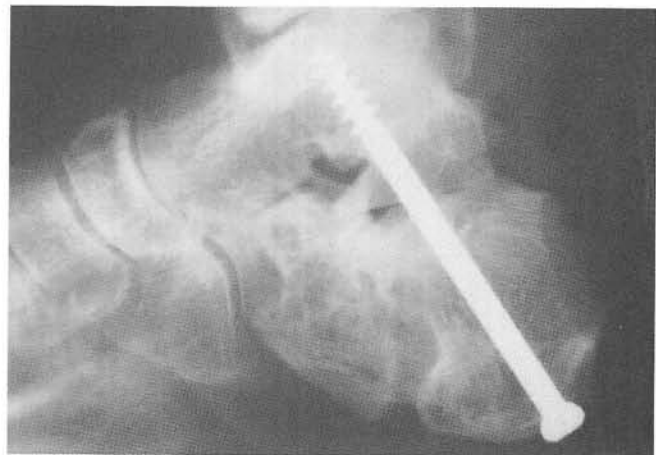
Final intraoperative lateral radiograph showing position of rearfoot and fixation.
